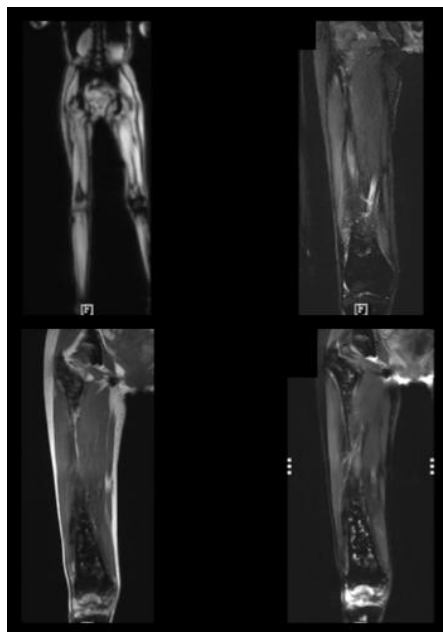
Non-contrast magnetic resonance imaging of the right femur (T1-weighted and T2 STIR/fat-suppressed sequences, multiplanar). There is diffusely low marrow signal consistent with widespread hemosiderin deposition throughout the visualized bone, together with hemosiderin deposition within the right rectus femoris muscle, providing direct evidence of iron toxicity in both bone and adjacent soft tissue.<sup>9</sup>
